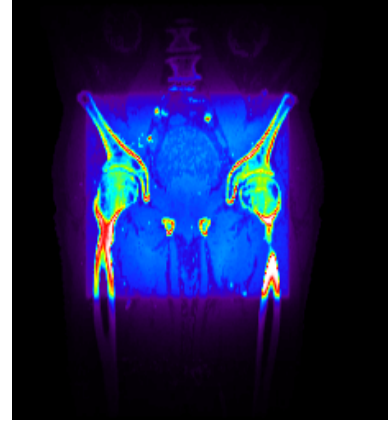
Isocentric slices for Pat. D for a single beam at 0° . The slice positions are marked in the CT-slices shown in (n) - (p).
